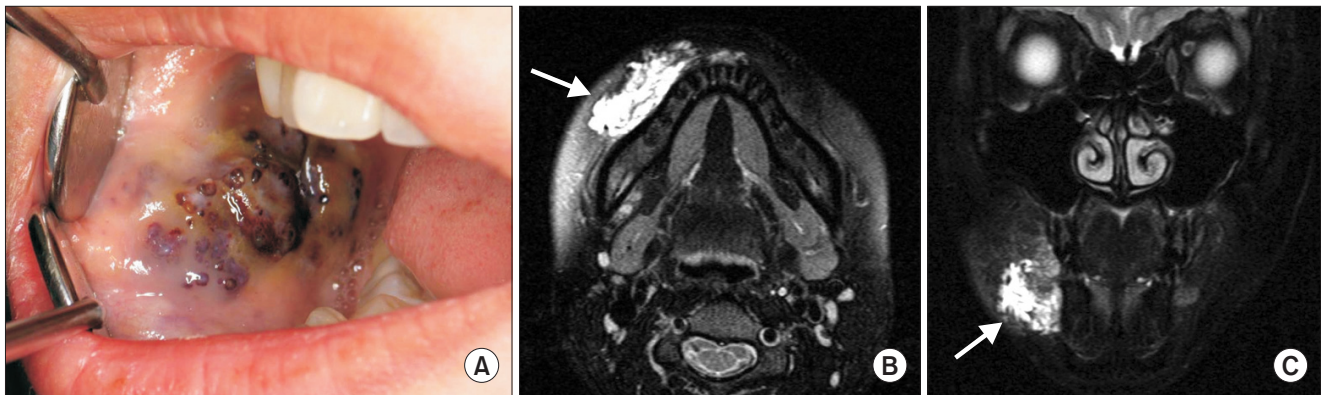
Preoperative clinical and magnetic resonance imaging (MRI) findings. A. Primary lesions presented as multiple, small, irregular, raised lesions on the right side of the buccal mucosa. B, C. MRI shows an ill-defined heterogeneously enhanced lesion on the right side of the cheek (arrows).
